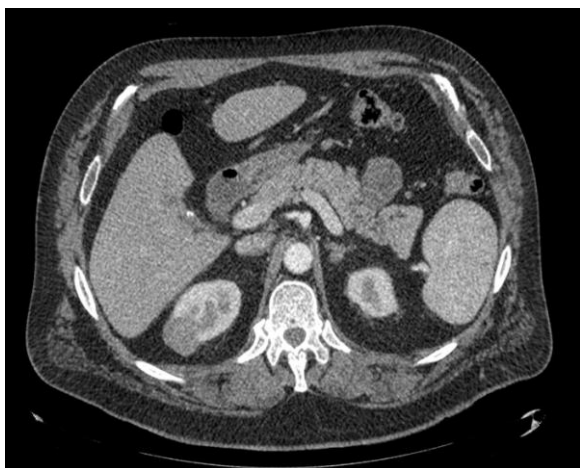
CT scan showing right renal cortical cystic mass grade 4 in Bosniak classification
